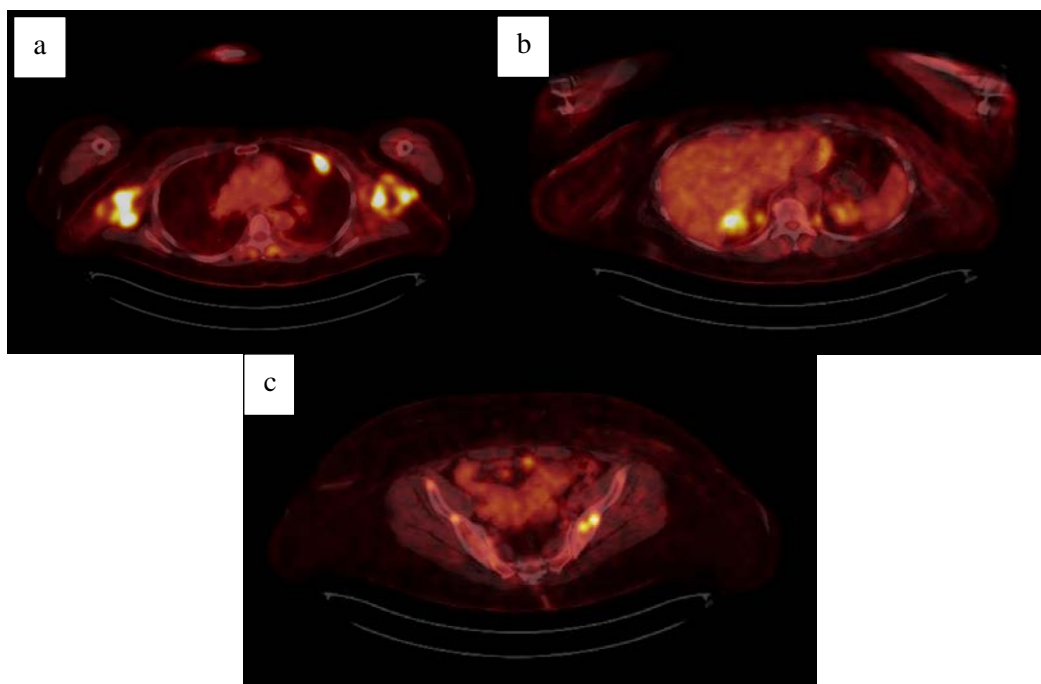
PET-CT of patient 3 showing extensive metastatic disease to axillae & lung (a), right suprarenal gland (b) and pelvis (c).
